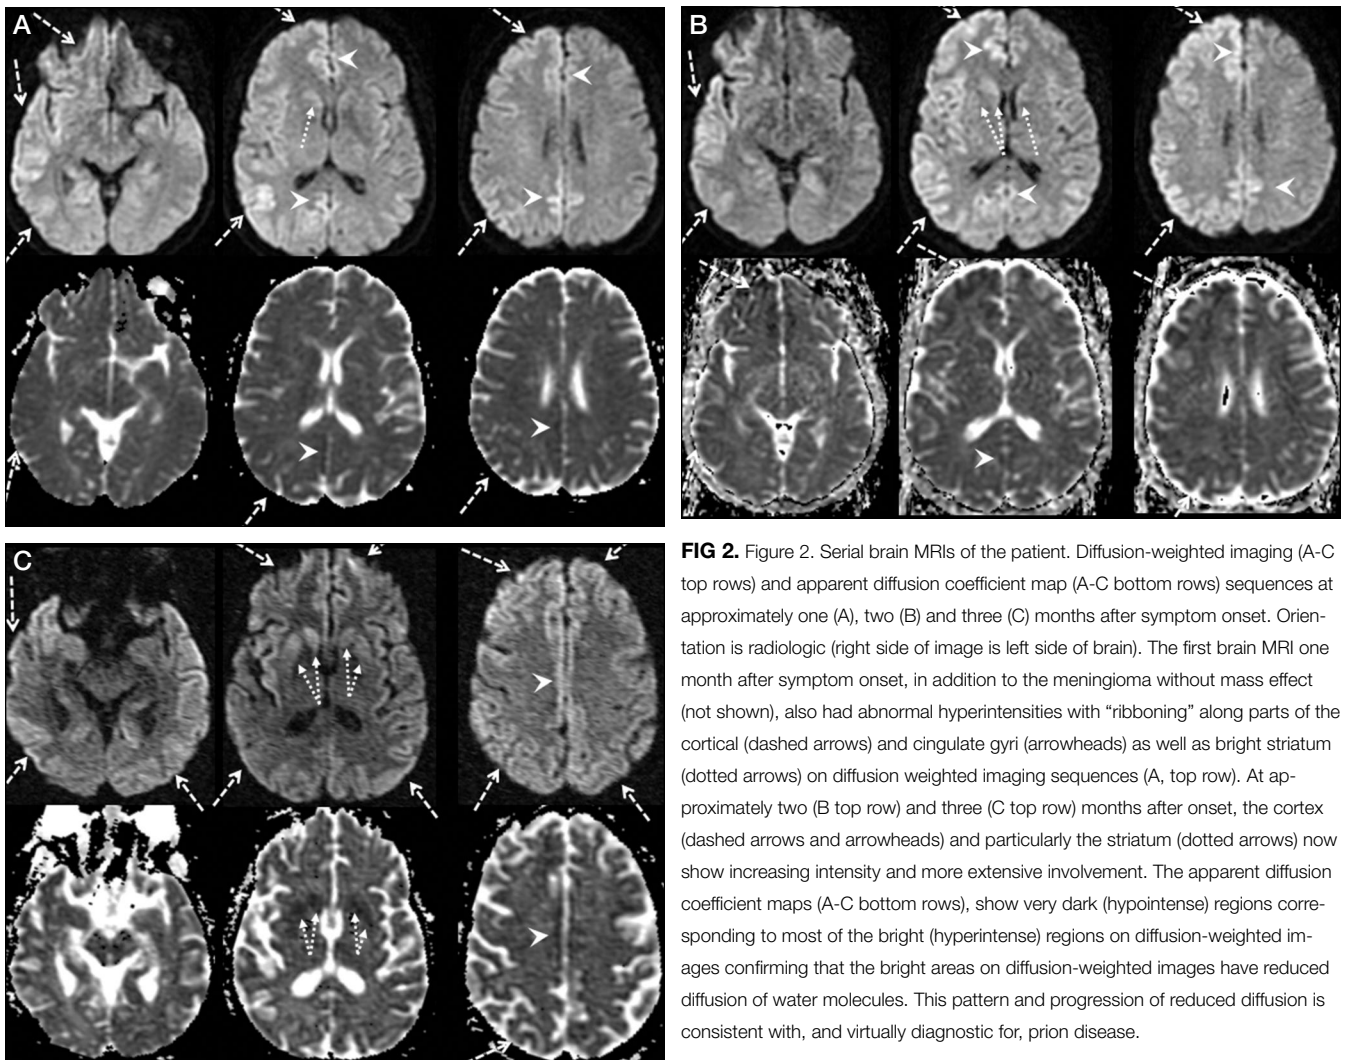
Figure 2. Serial brain MRIs of the patient. Diffusion-weighted imaging (A-C top rows) and apparent diffusion coefficient map (A-C bottom rows) sequences at approximately one (A), two (B) and three (C) months after symptom onset. Orientation is radiologic (right side of image is left side of brain). The first brain MRI one month after symptom onset, in addition to the meningioma without mass effect (not shown), also had abnormal hyperintensities with “ribboning” along parts of the cortical (dashed arrows) and cingulate gyri (arrowheads) as well as bright striatum (dotted arrows) on diffusion weighted imaging sequences (A, top row). At approximately two (B top row) and three (C top row) months after onset, the cortex (dashed arrows and arrowheads) and particularly the striatum (dotted arrows) now show increasing intensity and more extensive involvement. The apparent diffusion coefficient maps (A-C bottom rows), show very dark (hypointense) regions corresponding to most of the bright (hyperintense) regions on diffusion-weighted images confirming that the bright areas on diffusion-weighted images have reduced diffusion of water molecules. This pattern and progression of reduced diffusion is consistent with, and virtually diagnostic for, prion disease.
